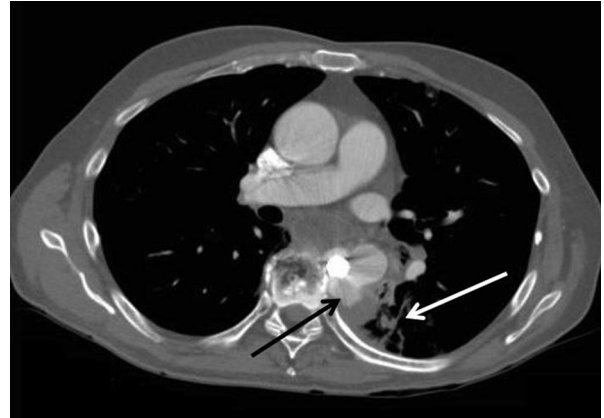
Computed tomography chest scan 5 years post spinal surgery at level T7 showing the pseudoaneurysm (black arrow) and extravasations of contrast (white arrow).
